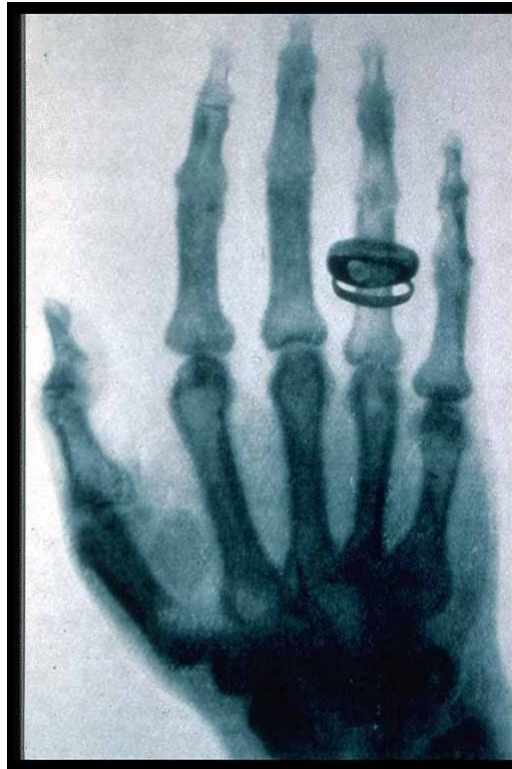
Reproduction of X-ray Image of Mrs. Röntgen's Hand. This image is considered one of the earliest x-ray images ever acquired. Note that the bone structure and metal ring are of significantly darker intensity versus the soft tissues of the hand and fingers, indicative of their higher material density.
